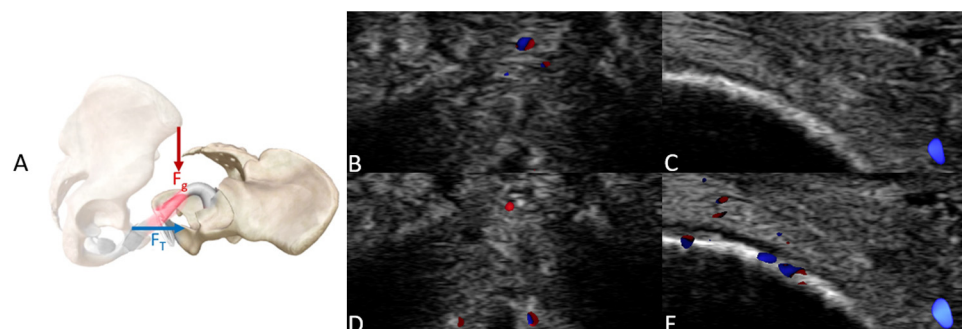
Biomechanical model of the face-to-face/male above position (a). The thrusting force ( $F_T$ ) is provided by the male pelvis, and is approximately perpendicular to the gravitational force of the male pelvis ( $F_g$ ). Transverse and sagittal views of the clitoris before (b and c) and after (d and e) engaging in the face-to-face/male above position, with color Doppler flow.
